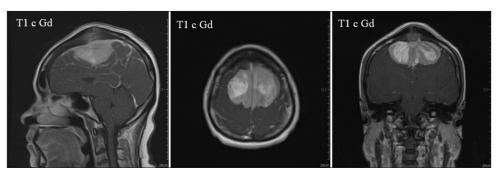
T1-weighted imaging with gadolinium injection revealed bilateral parasagittal meningiomas occupying both supplementary motor area areas. Bone hyperostosis was observed with a slightly increased intensity in the bone cortex, which reflected tumor infiltration.
